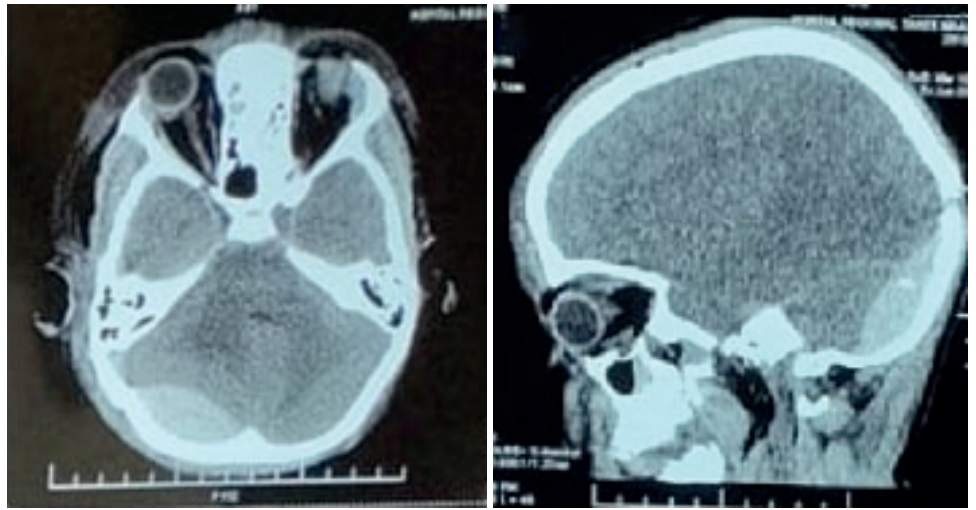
Axial brain computed tomography scan showing a right Supratentorial infratentorial epidural hematoma.
